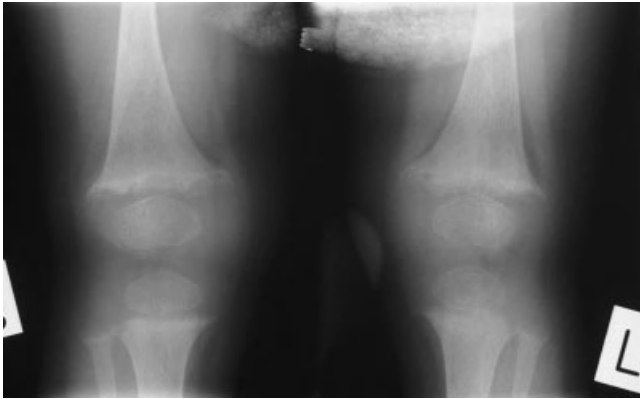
Radiographic image of lower end of femur and upper tibia in an infant suffering from severe neonatal primary hyperparathyroidism. Note the “moth-eaten” appearance and the similarity to that of rickets. This infant’s chest radiograph showed the presence of multiple rib fractures and cystic areas, and he was ventilator dependent for several weeks prior to parathyroid gland removal. He then developed a severe “hungry bone” syndrome requiring infusion of large quantities of calcium to prevent symptomatic hypocalcemia. Reproduced by kind permission of Dr William Van’t Hoff.
